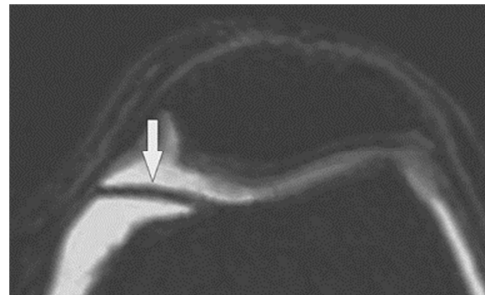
Axial fat-suppressed, T2-weighted MR image of mediopatellar plica
